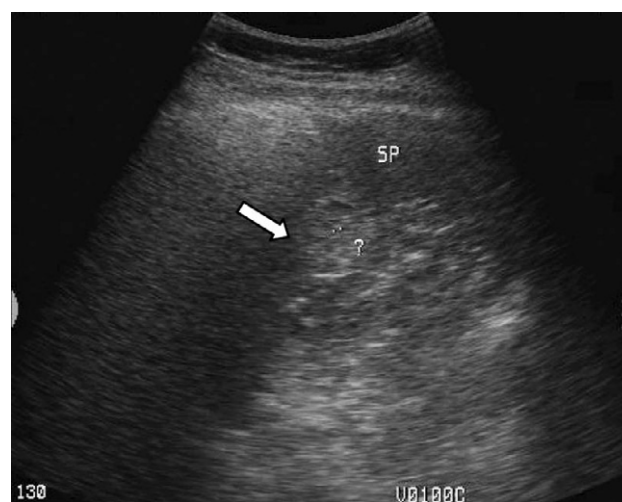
Abdominal ultrasonography showed an echotexture spleen with hyperechoic lesions (arrowhead).
